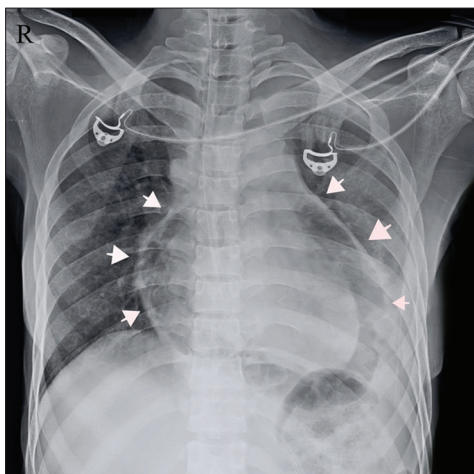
Chest radiograph – anterior– posterior view (white arrows) showing cardiac silhouette is partially surrounded by a rim or air-density suggestive of a pneumopericardium
